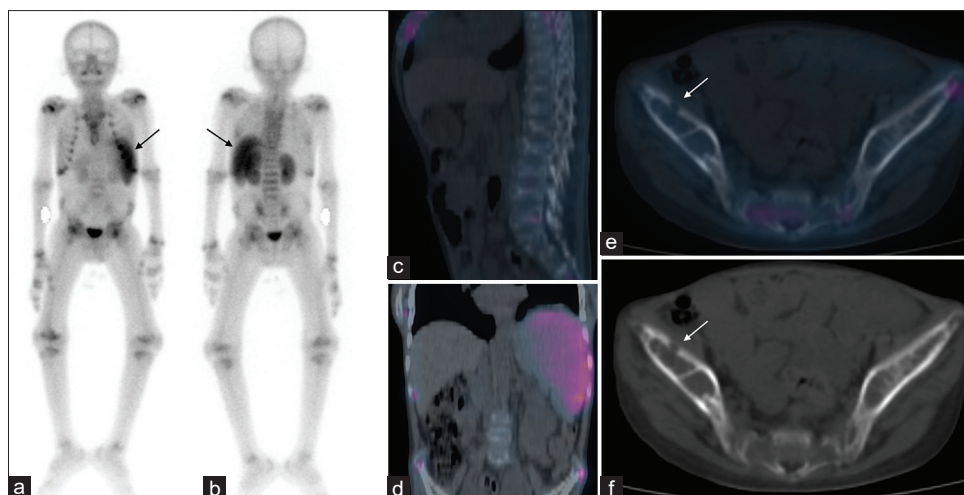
Planar (a anterior and b posterior) and single photon emission computed tomography/computed tomography (c-f) ^{99m}Tc-Methylene Di-Phosphonate images in a 12-year-old boy with relapsed acute lymphocytic leukemia. Planar images revealed reduced vertebral height and diffuse uptake in the spleen (black arrows). Single photon emission computed tomography/computed tomography showed osteopenia and reduced vertebral height (c), which was consistent with past bone marrow infiltration. Furthermore, diffuse uptake in the spleen was confirmed (d). Finally, a “cold” lytic lesion was seen in the right ilium (white arrows, e and f), which was clinically deemed to be active involvement in view of active disease in the bone marrow
